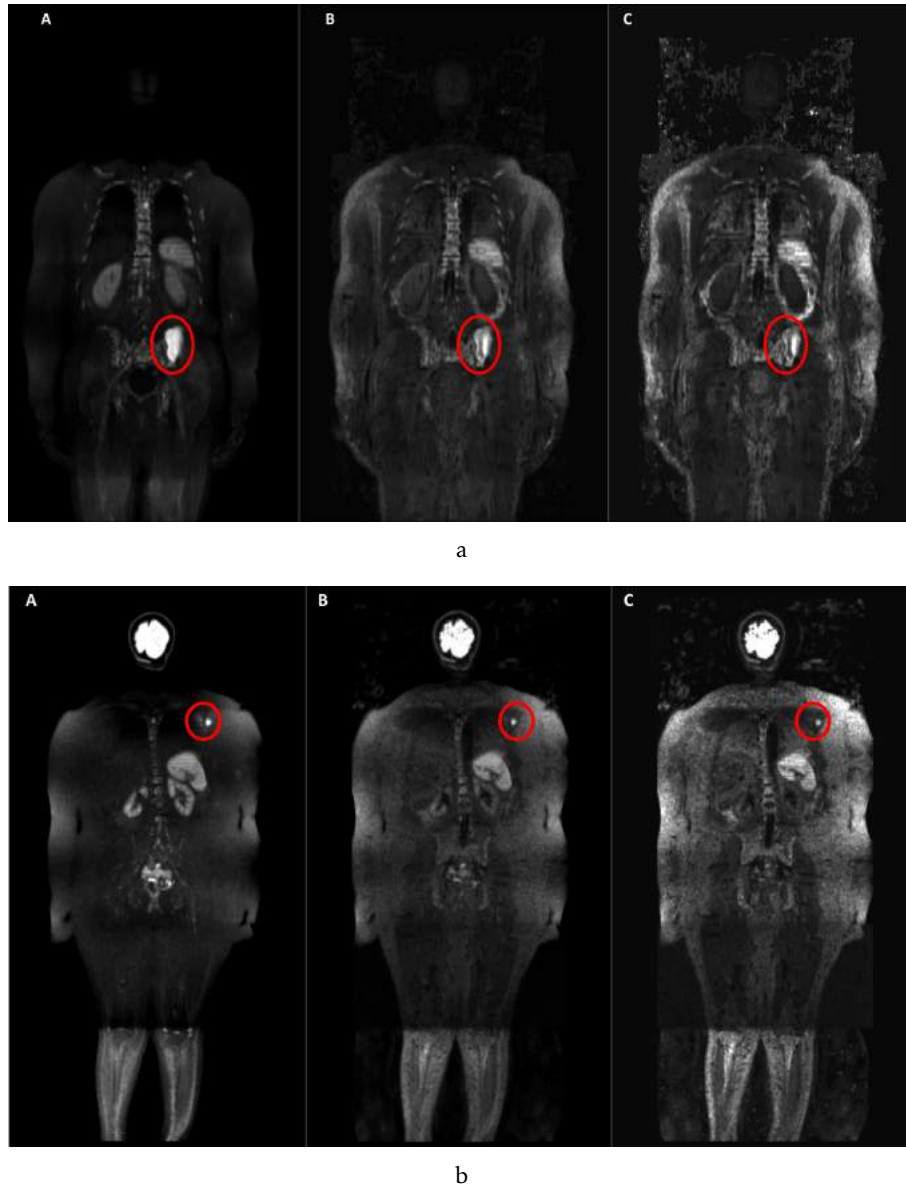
Three different b-values applied to a male (a) and female image (b). A- b-value acquired directly from MRI (800 or 1000 s/mm²); B- computed b-value (1500 s/mm²); C- computed b-value (2500 s/mm²). The red circle contours a possible lesion, hyperintense in all b-values. It is possible to see the contrast differentiation between normal and diseased (red circle) tissues when increasing the b-value. However, the 2000 s/mm² b-value image is very noisy, being hard to distinguish a lesion from the arm hyperintensities, due to the use of surface coils.
